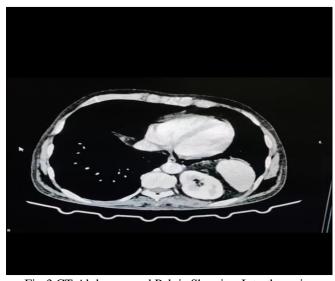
CT Abdomen and Pelvis Showing Intrathoracic Kidney and Spleen
